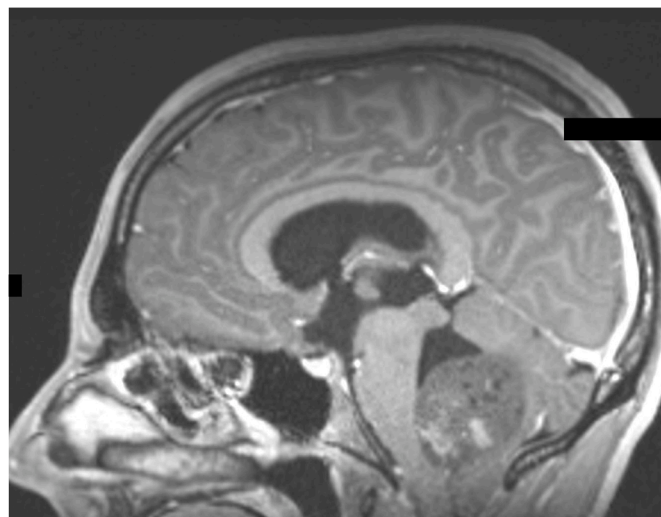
T1 post-contrast MRI demonstrating large posterior fossa mass lesion causing obstruction of the 4th ventricle.
